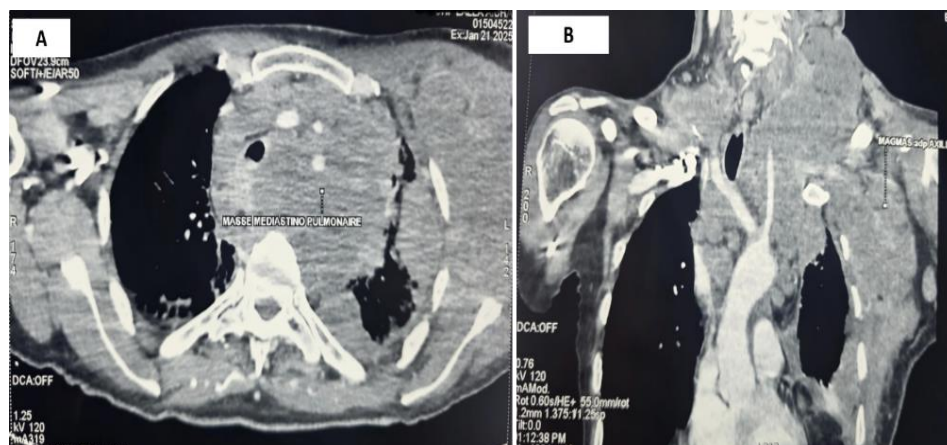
Thoracic CT scan: (A) heterogeneous left mediastinal mass (82 × 96 × 190 mm) with irregular margins; (B) multi-regional lymph node enlargement.
